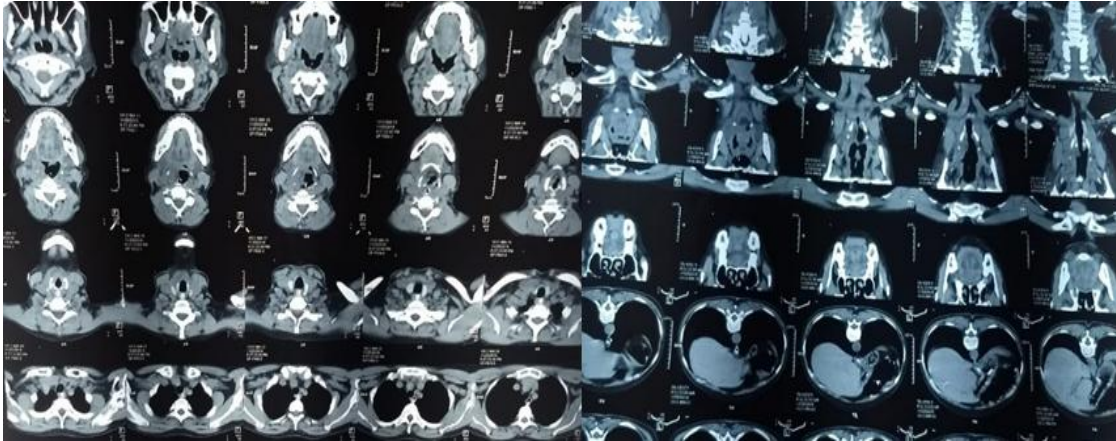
Axial and Coronal view CT scan larynx showing mass lesion involving laryngopharynx.
